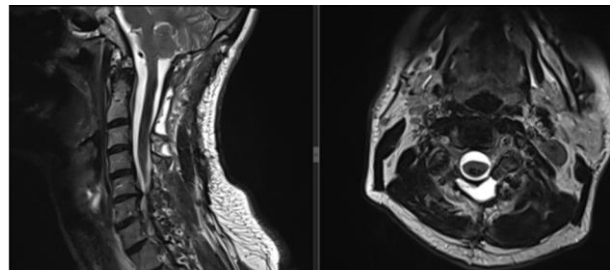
Postoperative MRI – 2 months after surgical intervention. The spinal cord presents a normal signal, without signs of compression, and no blood signal in the tumoral bed.
